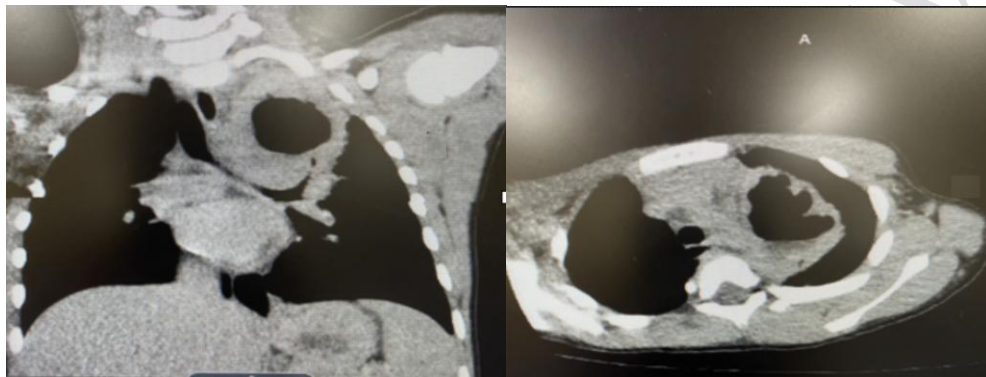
The patient's CT chest with contrast showing large gas and fluid containing collection in the left upper lobe with irregular wall confirming what was seen in ultrasound and CXR
